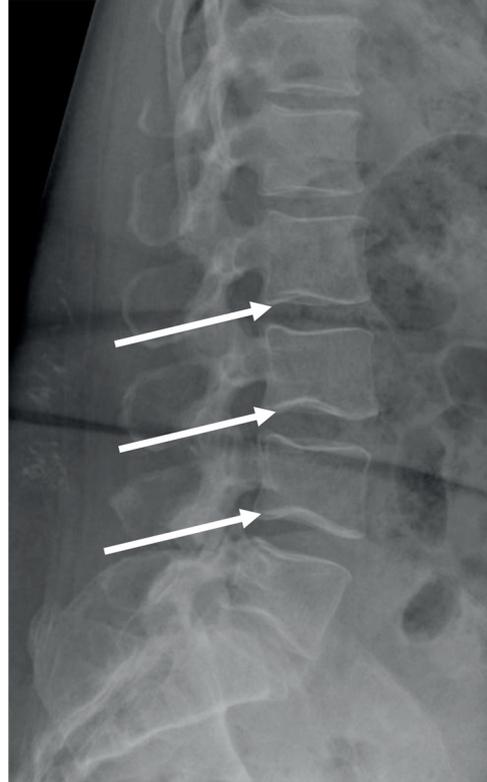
Lateral radiograph of the lumbar spine demonstrates deep inferior endplates at multiple levels (arrows).
